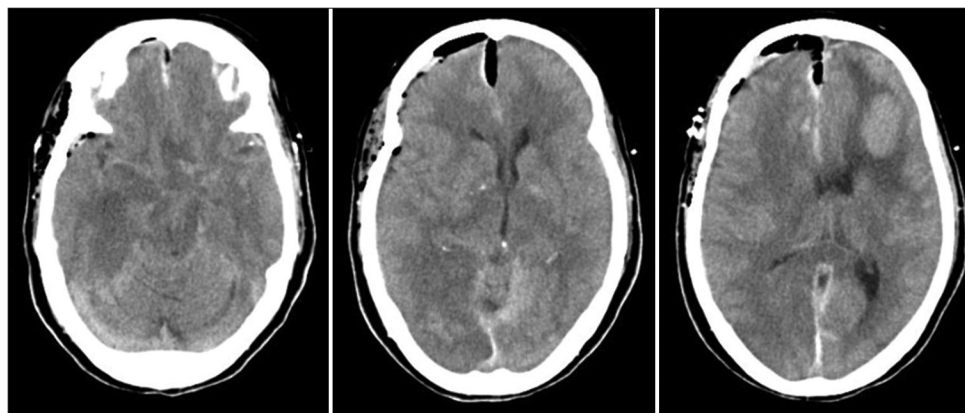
Postoperative computed tomography reveals removal of acute subdural hematoma.
